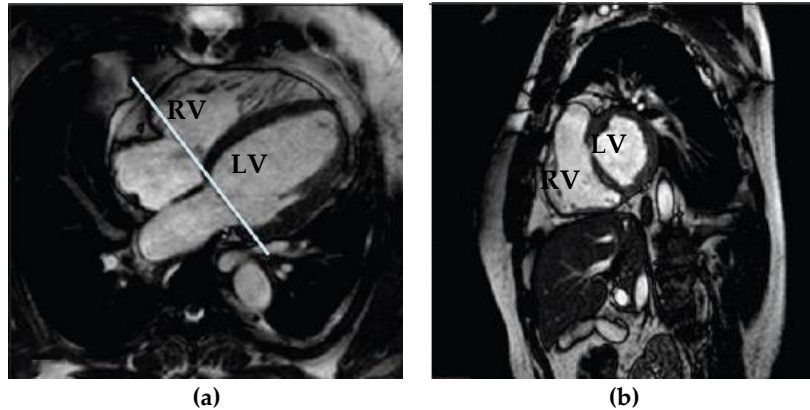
Cardiac MRI in diastolic phase (a) Long axis slice, (b) Short axis slice [10]
